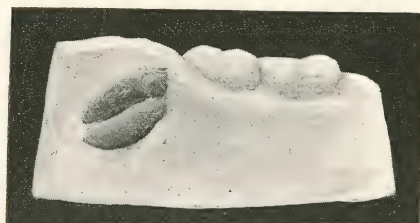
The model at the left shows the remains of a third molar. It was supposed to have been extracted a year previous and was entirely invisible, being covered by the gum. By the aid of the skiagraph it was easily discovered and removed. The picture on the right shows the root of a lower bicuspid which was invisible to the eye. The X-ray made it easily removed.
